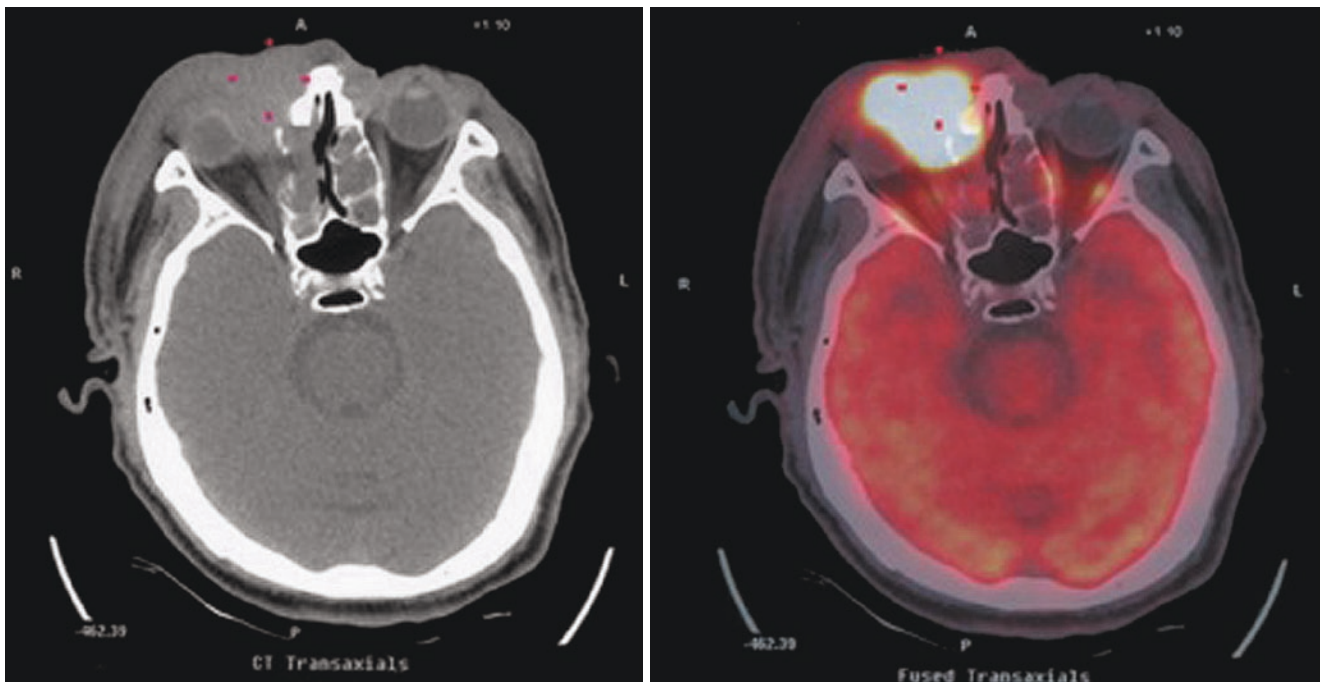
PET/CT shows right facial soft tissue-occupying lesion penetrating into the eye, SUVmax33; the pathological diagnosis was diffuse large B-cell lymphoma
